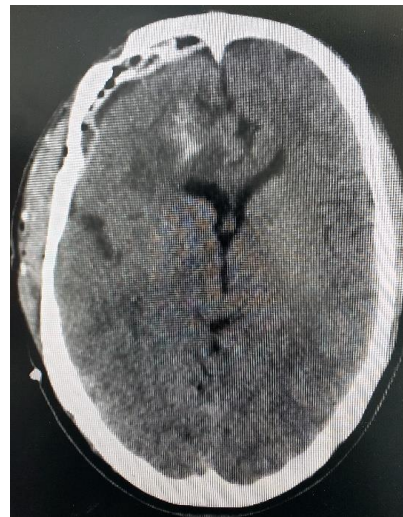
Post-operative CT: note the disappearance of the shift effect after cysts removal.
